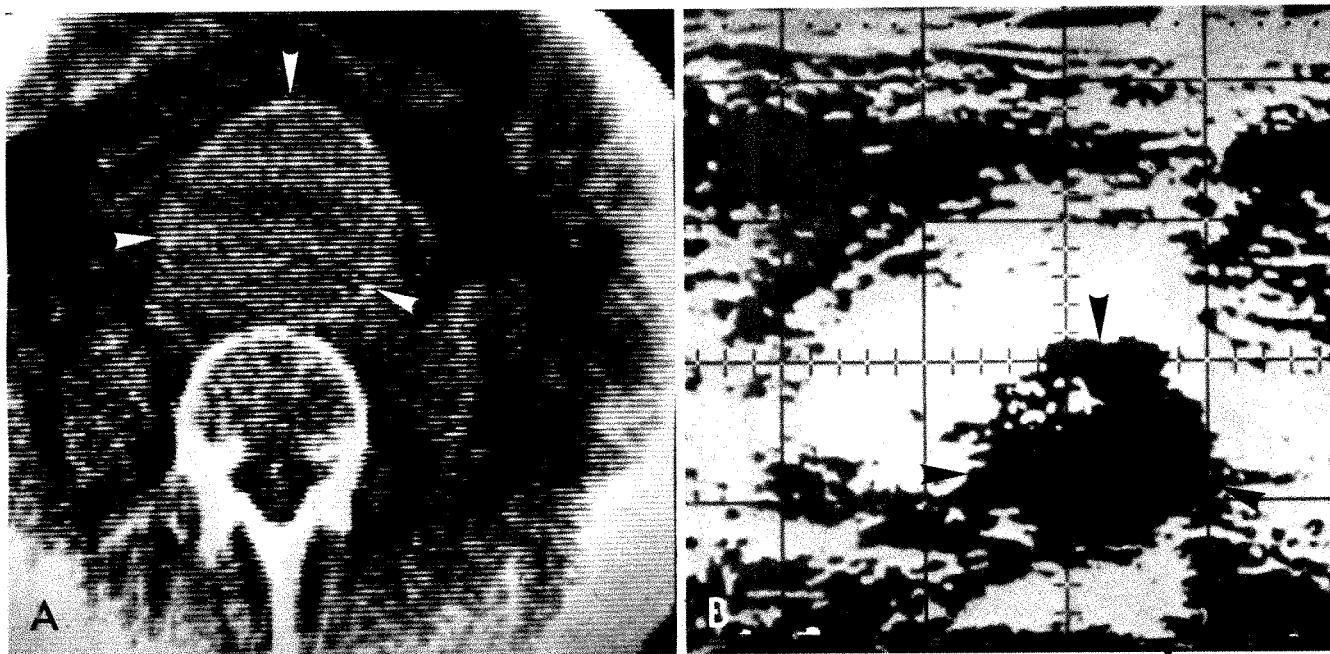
A, Abdominal aortic aneurysm (arrows) with calcific wall measuring 8 cm. Size estimate based on 1:4.2 scale measured from Polaroid print. B, Sonogram at same level showing 8 cm aneurysm (arrows). Crosshatches represent 1 cm intervals. Measurement confirmed at surgery.
